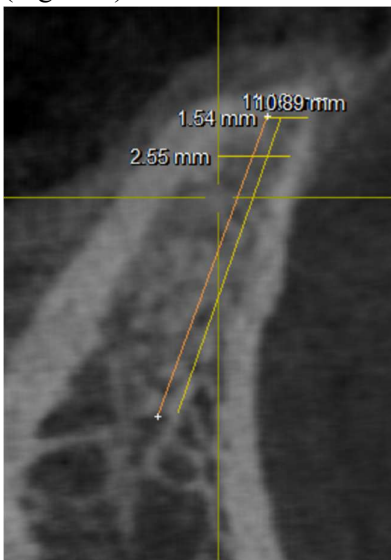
Cross-sectional view of CBCT
